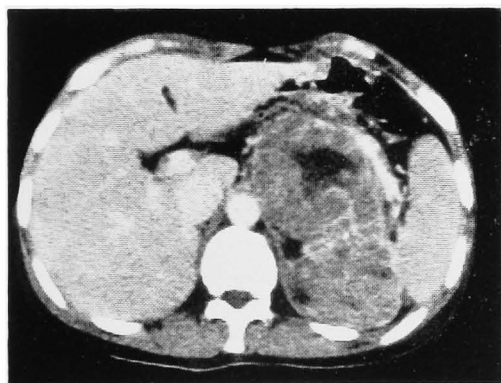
A computed tomograph shows a huge inhomogenous tumefaction on the left side of abdomen.
